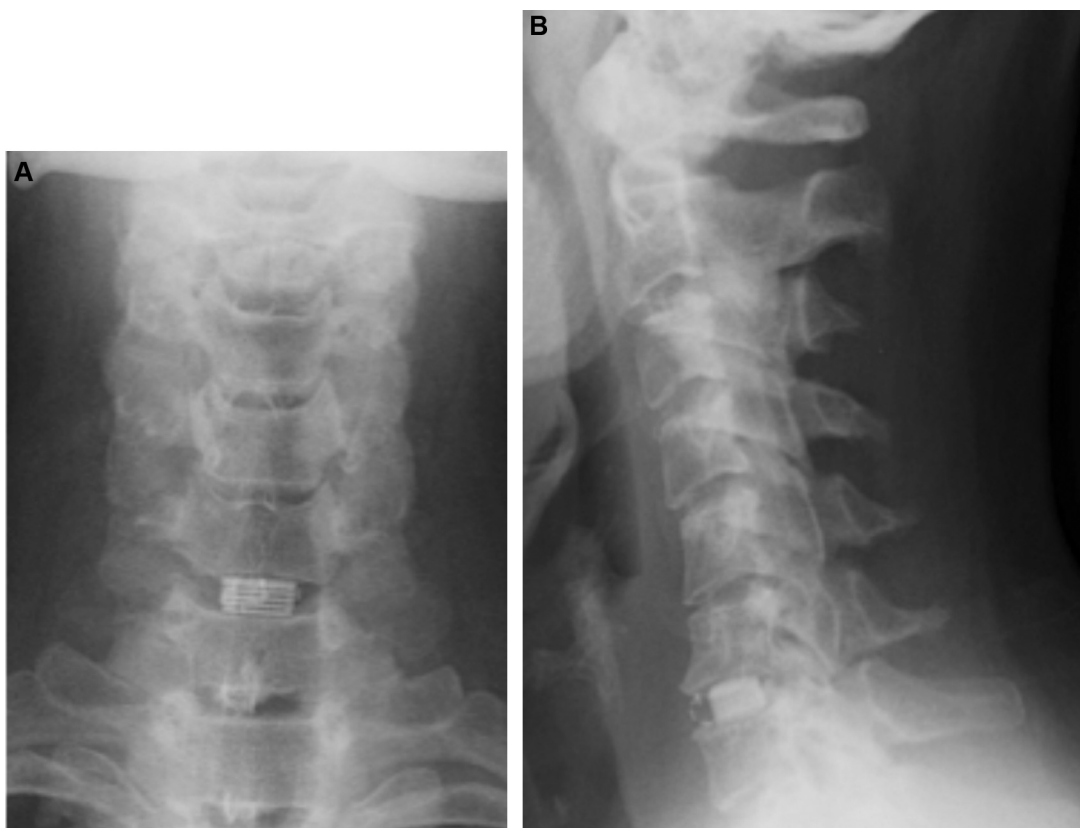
Radiographs of the cervical spine, antero-posterior (A) and lateral (B) projections: the cage is visible in the C6–C7 space.
